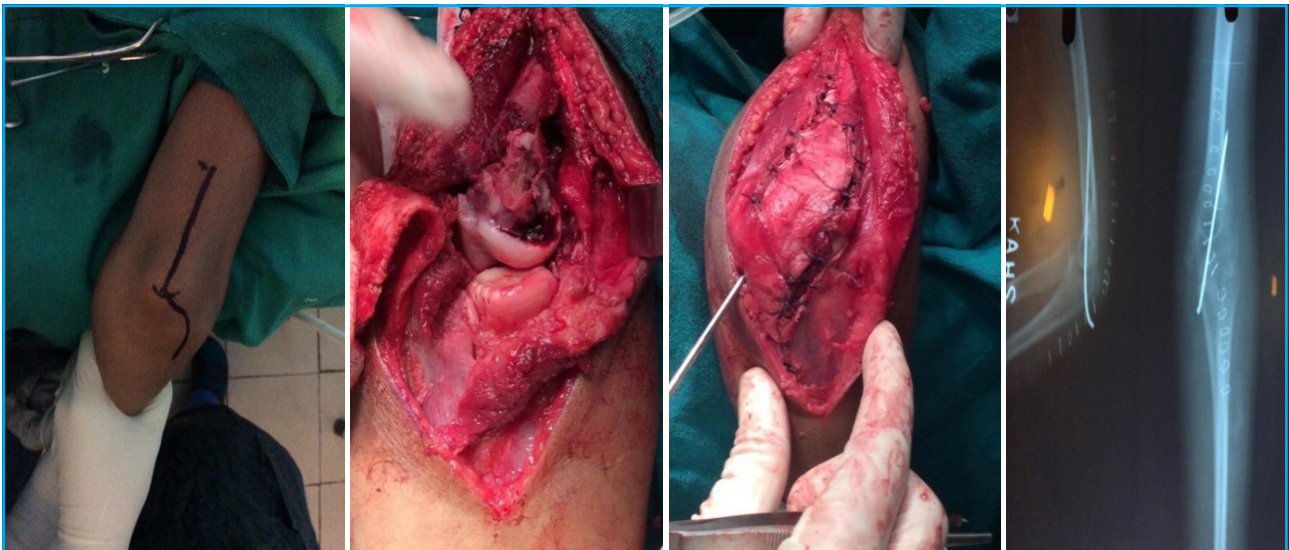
Intraoperative pictures and post-operative radiograph with transolecranon K wire.
